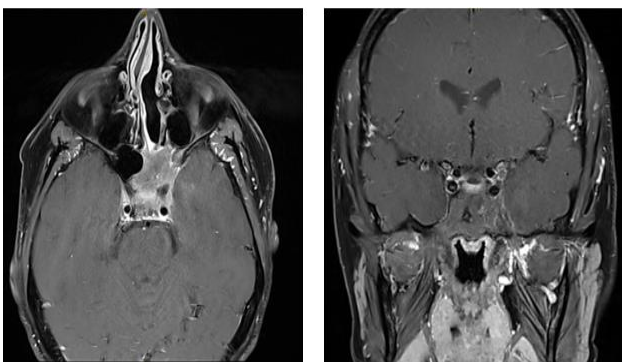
T1 post Gad axial and coronal MRI through the sphenoid sinus. Demonstrating appearance of disease burden 5 months after treatment. There is near complete resolution of the intra-canal disease with significant reduction of the paranasal sinus disease.
